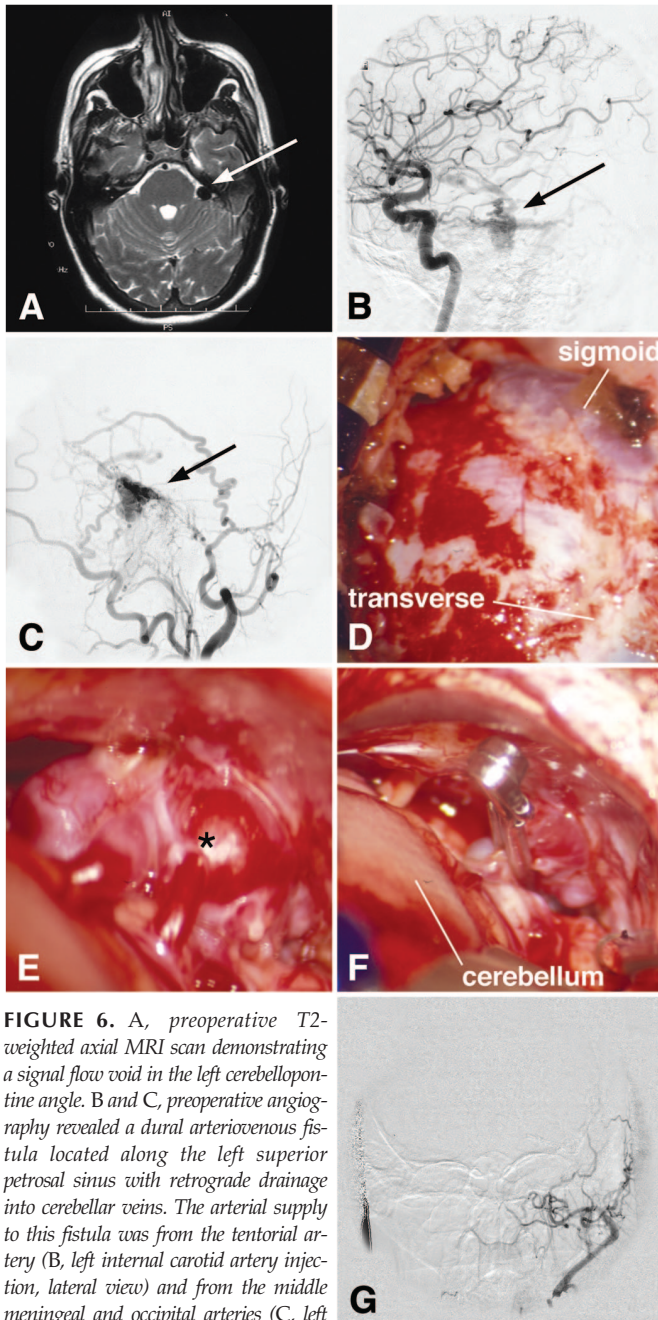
A, preoperative T2-weighted axial MRI scan demonstrating a signal flow void in the left cerebellopontine angle. B and C, preoperative angiography revealed a dural arteriovenous fistula located along the left superior petrosal sinus with retrograde drainage into cerebellar veins. The arterial supply to this fistula was from the tentorial artery (B, left internal carotid artery injection, lateral view) and from the middle meningeal and occipital arteries (C, left external carotid artery injection). D, the extended retrosigmoid approach exposed the transverse and sigmoid sinuses and the lateral posterior fossa dura. E, the arterialized varix draining the fistula was identified in the angle between the tentorium and posterior petrous bone, and multiple arterialized veins originating from the varix coursed over the cerebellar surface (asterisk). F, the DAVF was occluded with an aneurysm clip placed across the varix, which was then coagulated and divided. G, postoperative angiogram showed complete elimination of the fistula (left external carotid artery injection, anterior-posterior view).
